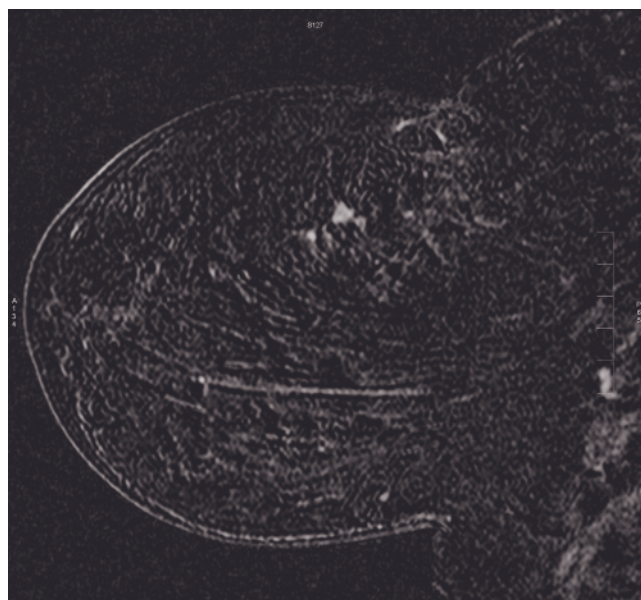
Altering IDC appearance in course of neoadjuvant chemotherapy. Multiple MR exams in the sagittal plane, postcontrast 3D GRE T1-weighted scans, without and with subtraction, at approximately the same level. Initial study (*a, b*) demonstrates an irregular, strongly enhancing mass with irregular borders and rim enhancement. There is associated non-masslike enhancement in a segmental distribution posterior to the mass and an area of clumped enhancement in a ductal distribution at the posterior and superior border of this area, compatible with DCIS. Diffuse skin thickening is evident, most pronounced at the nipple-areolar complex. Note bright coil artifacts on the skin. The second study was performed at the middle point of chemotherapy (*c, d*): the mass is significantly smaller, non-masslike area of enhancement and clumped ductal enhancement reduced in size. The third study after completion of the 8 cycles of chemotherapy, before surgery (*e, f*), shows partial response.
